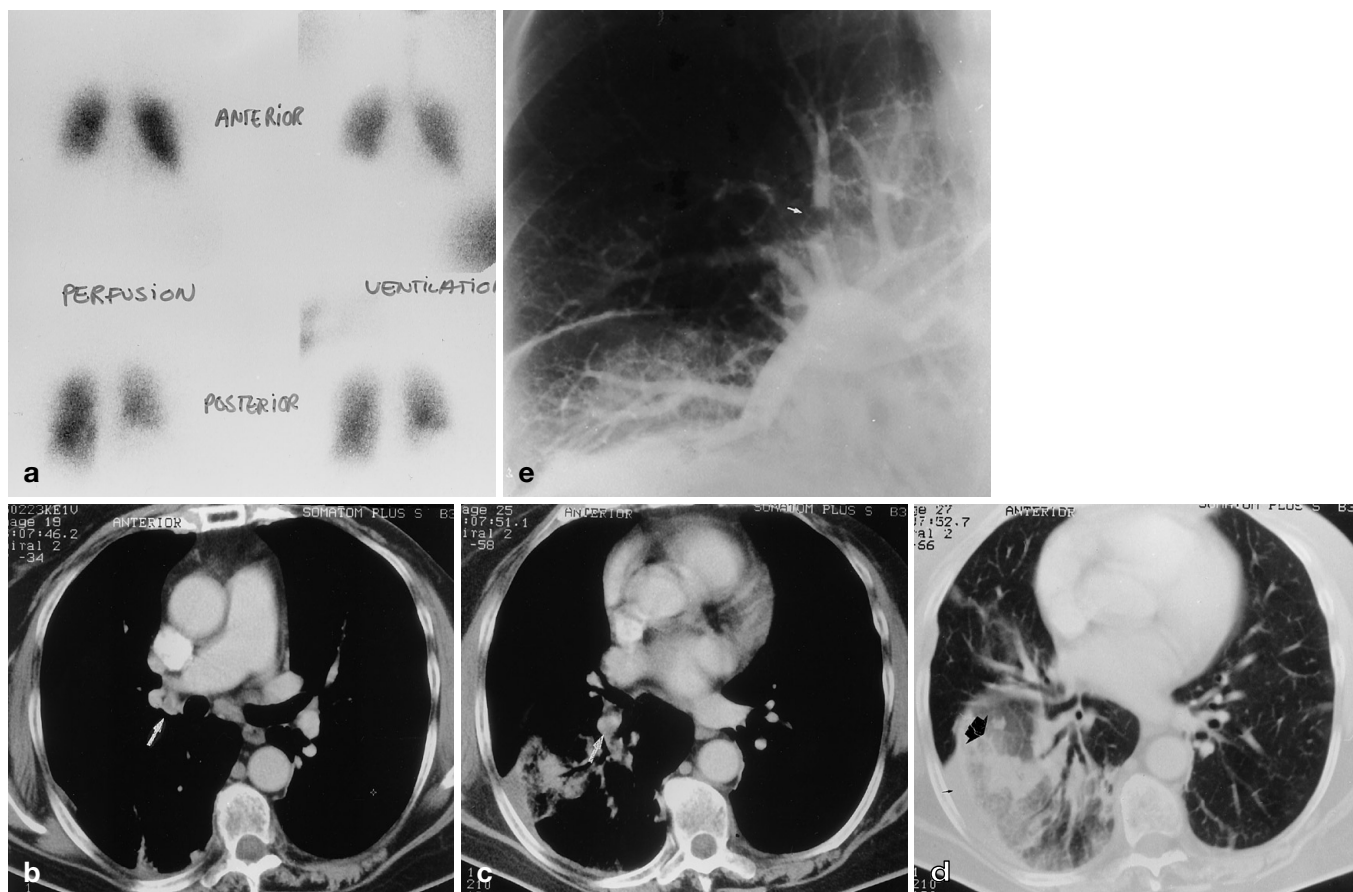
A 71-year-old woman with sudden onset of shortness of breath. Laboratory findings showed no abnormalities and the chest X-ray showed area of air-space consolidation in the right lower lobe (not shown here). a The V/Q scan shows matching defect of the right lower lobe on the anterior and posterior view. The panel scored the V/Q strategy as inconclusive. b The CT scan shows a filling defect in a right upper lobe segmental artery (*arrow*). c, d A CT scan at the level of the right lower lobe shows another filling defect in a lower lobe artery (*white arrow*) with an area of parenchymal consolidation (*black arrow*) and some pleural effusion (*small black arrow*). Panel scored this patient with CT strategy as present PE with pulmonary infarction. e Pulmonary angiography of the same patient confirmed CT findings, embolus in the right upper lobe (*arrow*)
